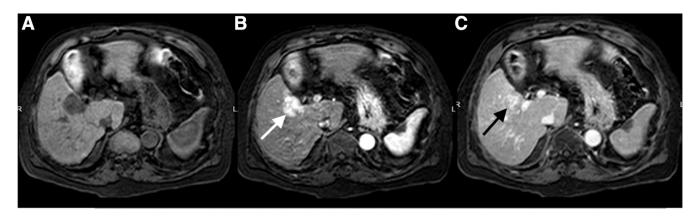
Initial liver protocol MRI in native (A), arterial (B), and venous (C) phases demonstrating the 3.3 cm lesion near the porta hepatis with the white arrow demonstrating arterial enhancement and the black arrow demonstrating washout.
